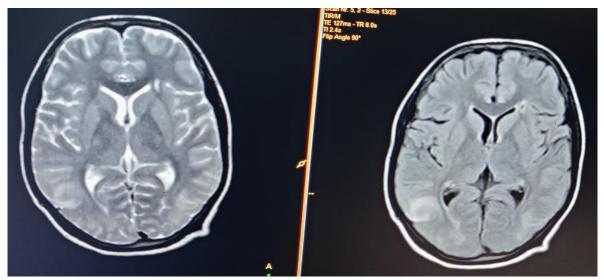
Axial T2-WI and FLAIR images showing confluent and focal area of T2/FLAIR hyperintensities noted in bilateral parietooccipital lobes-Typical PRES.
